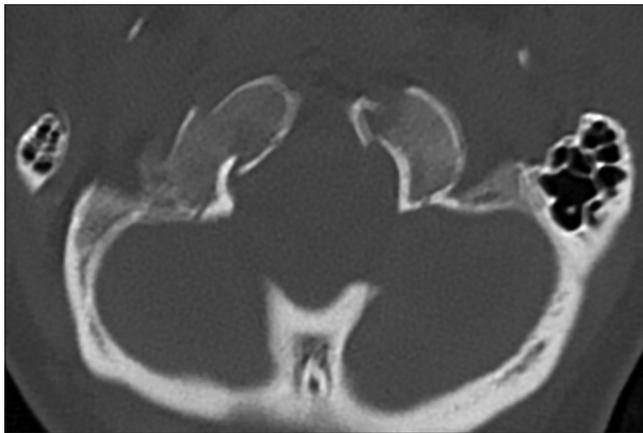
Computed tomography cervical spine (axial view) shows the bilateral occipital condyle fractures.
